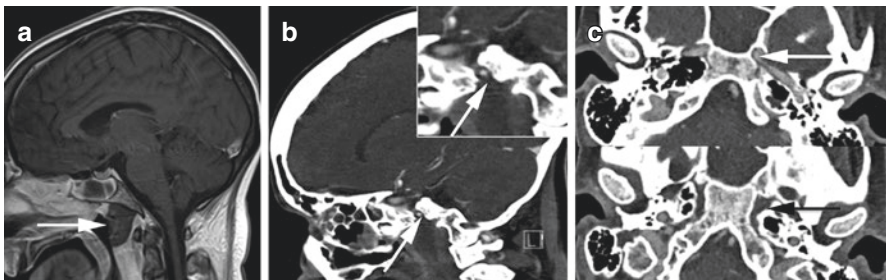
Lacerum internal carotid artery perivascular spread of infection. Patient with intracranial spread of nasopharyngeal mucor infection. Sagittal T1 postcontrast MRI (a) shows marked nasopharyngeal mucosal thickening with central nonenhancing tissue extending to the clivus, compatible with vasoinvasive fungal disease (arrow). Sagittal (b, inset) CTA shows perivascular spread of infection through the foramen lacerum with narrowing of the ICA lumen (arrow). Axial CTA (c) also shows asymmetric narrowing of the ICA (C top, white arrow) and extension through the foramen lacerum (C bottom, black arrow)
